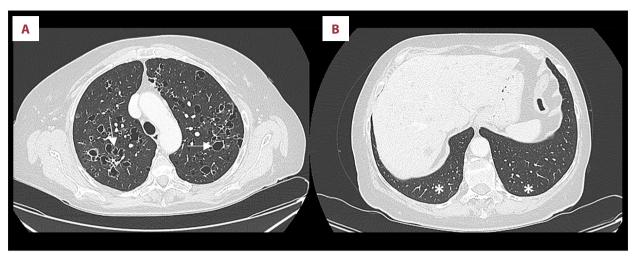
(A, B) axial thoracic CT images (lung window) shows typical confluence of cysts in bizarre shapes with predilection for the middle and upper zones (arrows) and regional sparing of the costophrenic recesses (asterisks).
